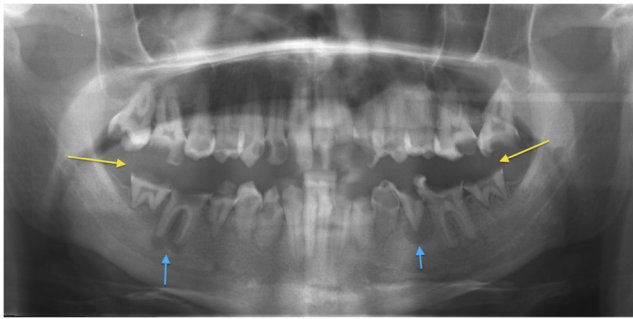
Dental caries (*yellow arrows*) secondary to enamel hypoplasia and xerostomia in a 20-year old treated with chemotherapy and mantle radiation for Hodgkin lymphoma stage IIIb at age 8 years. Multiple periapical lucencies (*blue arrows*) indicate granuloma formation after prolonged infection. (Photograph courtesy of Dr. Kaste)
